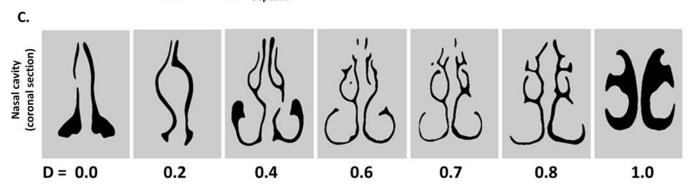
(A) CFD nasal airway (sagittal view) demonstrating 11 equally-spaced coronal crosssections. (B) Coronal CT of NAO patient at D=0.7. (C) Coronal cross-sections of nasal cavity at corresponding relative distance (D).
